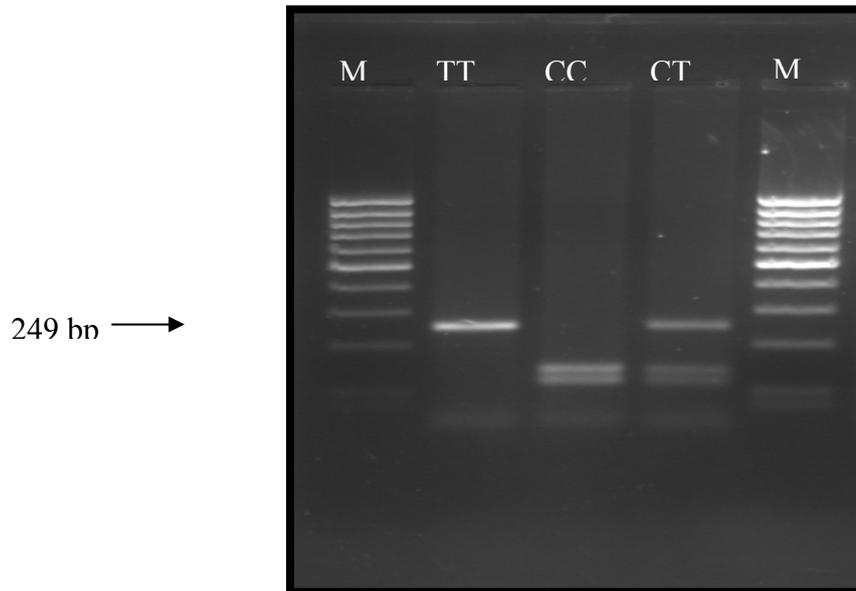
Differentiation of the IL-1+3953C/T promoters by *TaqI* digestion; M: ladder, TT: Thymine Thymine, CC: Cytosine Cytosine, CT: Cytosine Thymine
